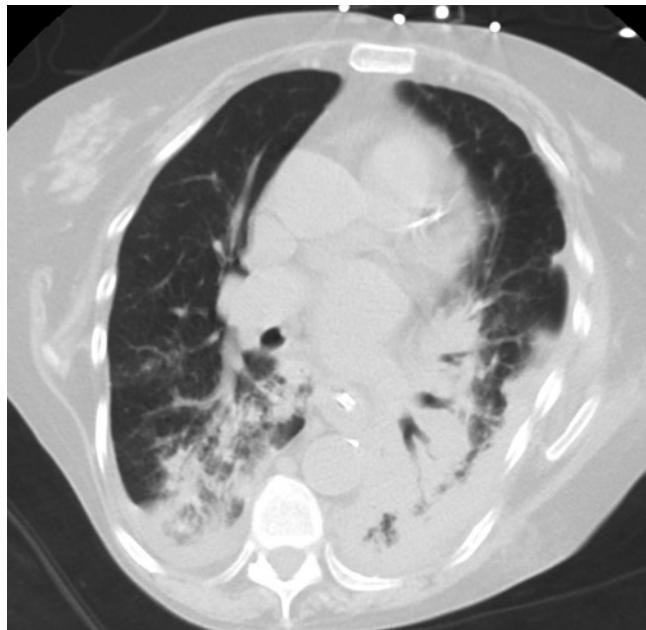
CT scan of the thorax which demonstrates multifocal bibasilar consolidations consistent with the patient's history of aspiration pneumonitis.
